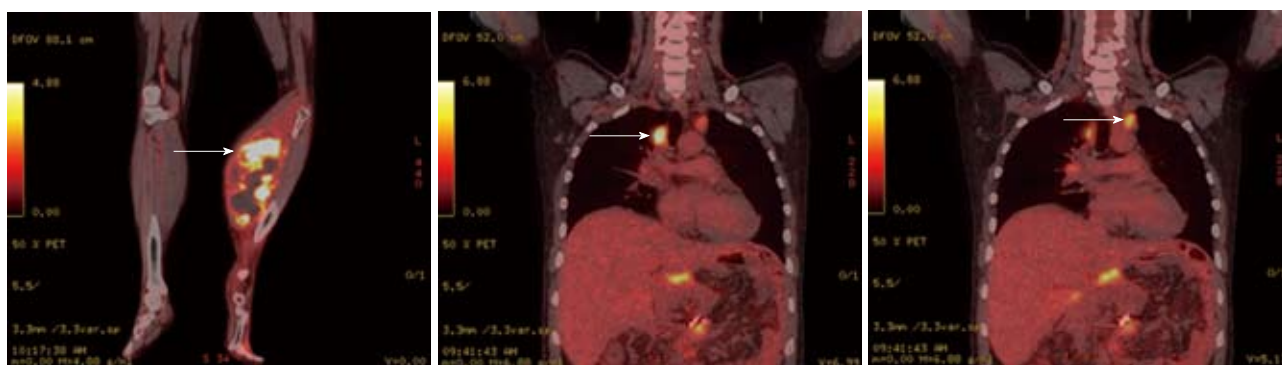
Positron emission tomography-computed tomography revealed high fludeoxyglucose uptake in the left leg and the relapse of carcinoma in both hila of the lungs.
